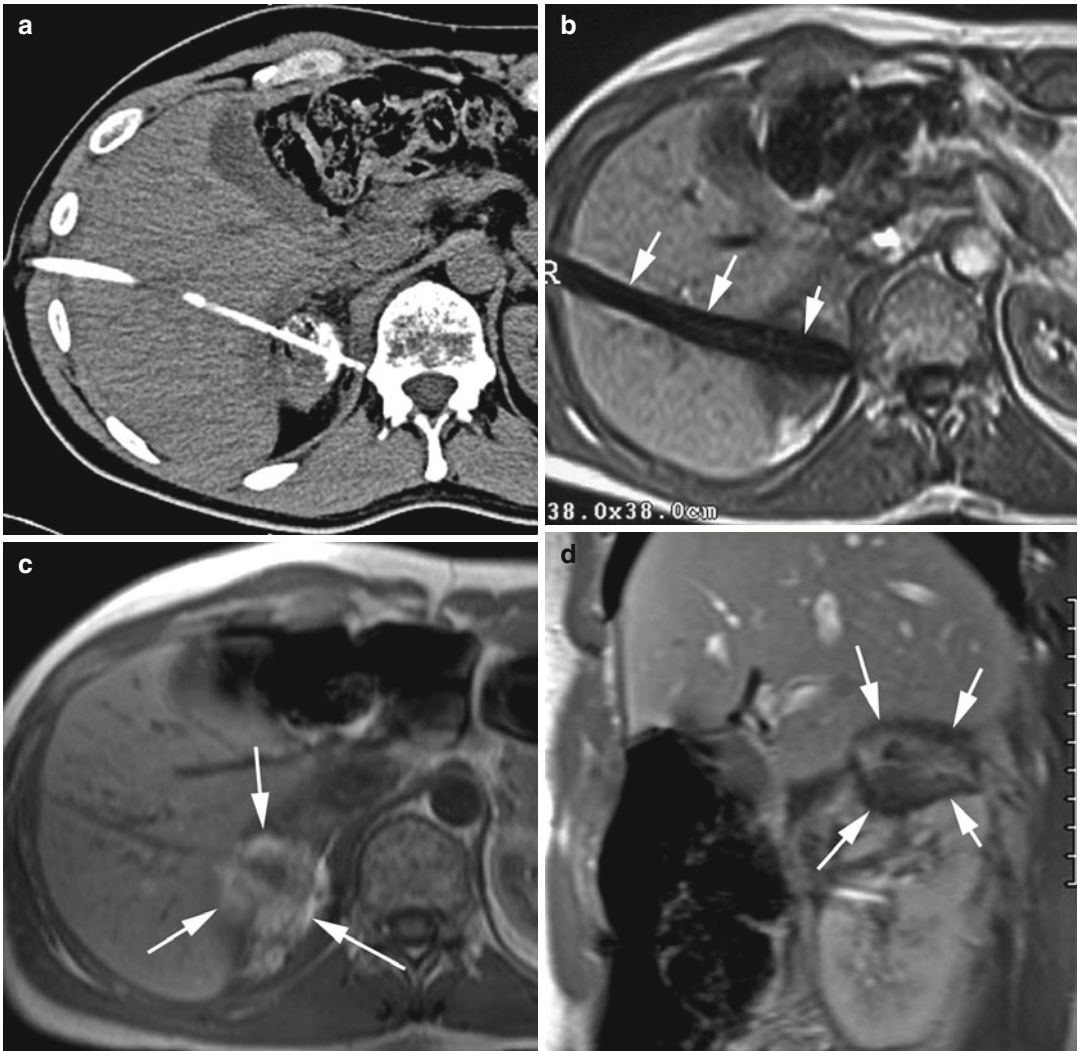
(a) CT-guided transhepatic placement of a laser application system in an embolized kidney carcinoma. (b) The gradient echo image is showing the susceptibility artifact of the laser application system due to the inserted magnetite marker (*arrows*) in order to verify the positioning on MR imaging. (c) The non-enhanced FLASH 2D image (sagittal view) 24 h after the ablation is
